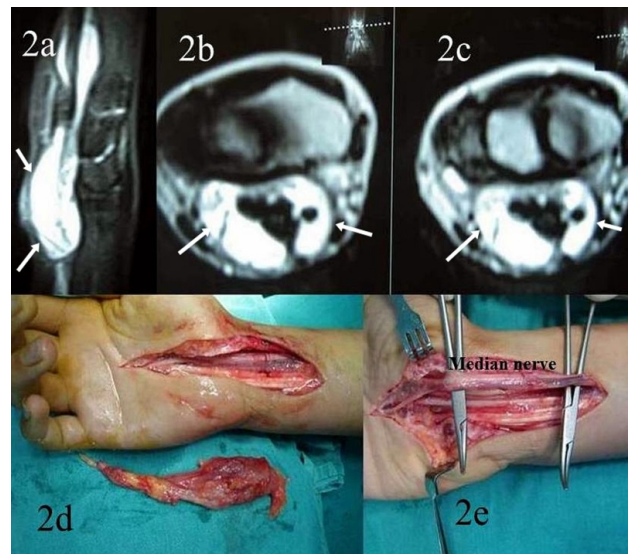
a, b and c Sagittal and axial magnetic resonance images of left wrist demonstrating hyperintense signal of the lipofibromatous hamartoma.
